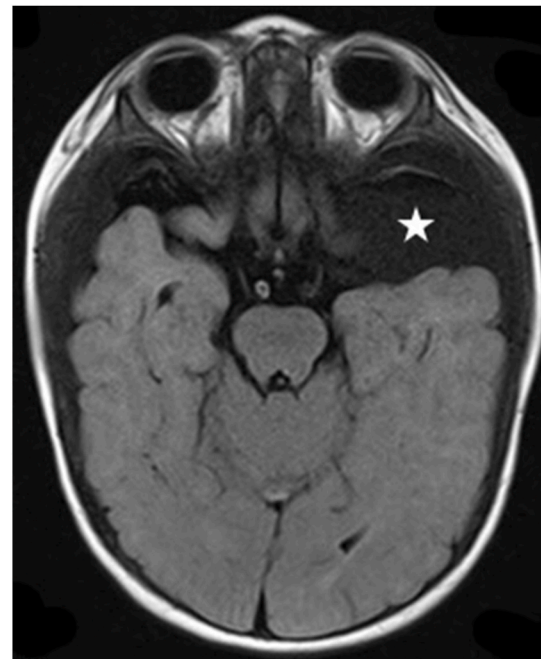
Axial FLAIR MRI of the brain with an extra-axial cyst in the left middle cranial fossa (marked by a white star).
